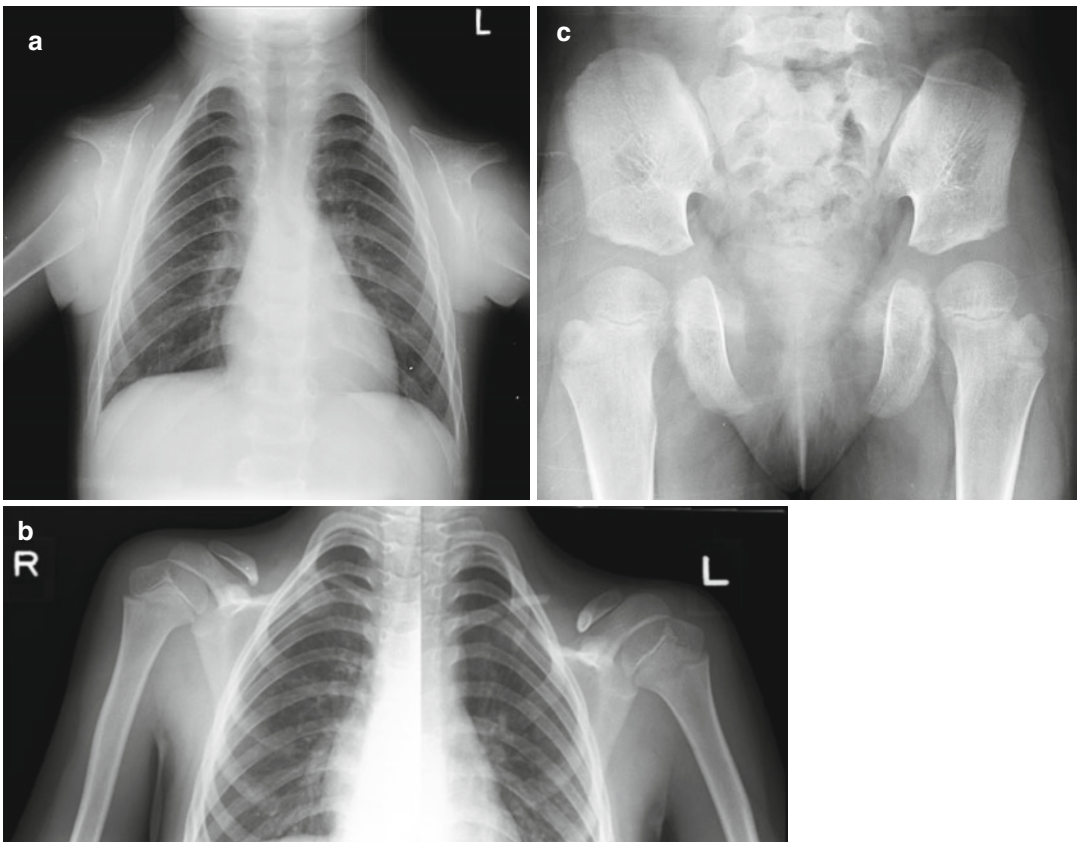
Radiographs of the chest of two children with craniocleidodysostosis; in one child, the clavicles are totally absent (a), while in the other child, the lateral ends of the clavicles are present (b). The pubic bones are also not formed (c)
